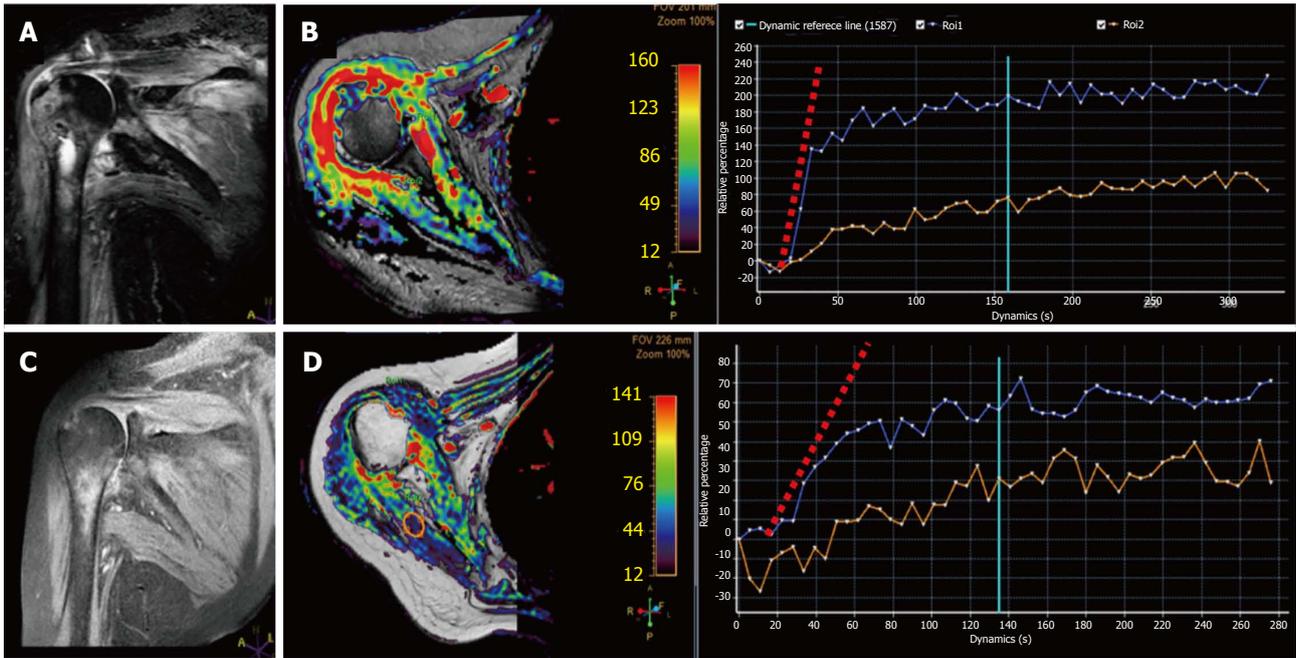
Magnetic resonance follow-up of septic arthritis in a 58-year-old woman with shoulder pain, fever, and swelling. A: Coronal STIR shows severe edema within the proximal humerus as well as in the surrounding soft tissues with minimal intraarticular fluid; B: DCE-MRI relative enhancement map demonstrates extensive enhancement in the synovium and the humeral head; C, D: Follow-up MRI study 3 wk after intravenous antibiotic therapy demonstrates adequate response to treatment with reduction of edema on STIR and enhancement on DCE-MRI. Note also the change in the initial slope of the blue TIC (synovial enhancement) between pre and post-treatment studies. The orange TIC shows healthy muscle contrast enhancement as an internal reference. STIR: Short inversion time recovery; DWI: Diffusion-weighted imaging; MRI: Magnetic resonance imaging; DCE: Dynamic contrast enhancement.
